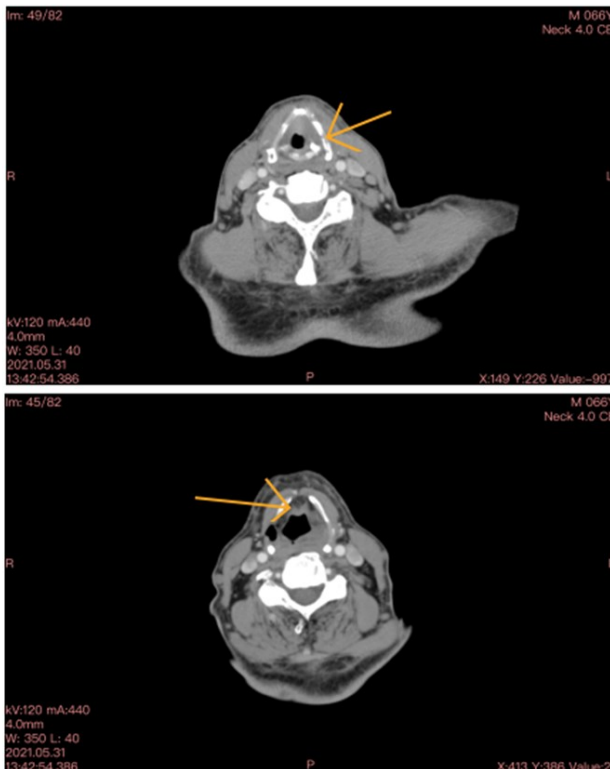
Case 2: A 65-year-old male patient presented with hoarseness of voice, cough, and neck pain that occurred occasionally. CT showed involvement of the anterior commissure and thyroid cartilage invasion.
